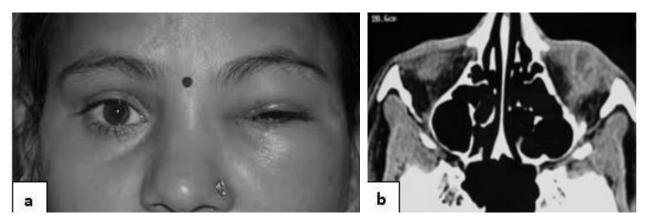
(a): Clinical presentation of preseptal cellulitis (left side)- eyelid oedema and erythema. (b): CT scan (axial section) - diffuse contrast enhancing soft tissue thickening anterior to the orbital septum (left side).
